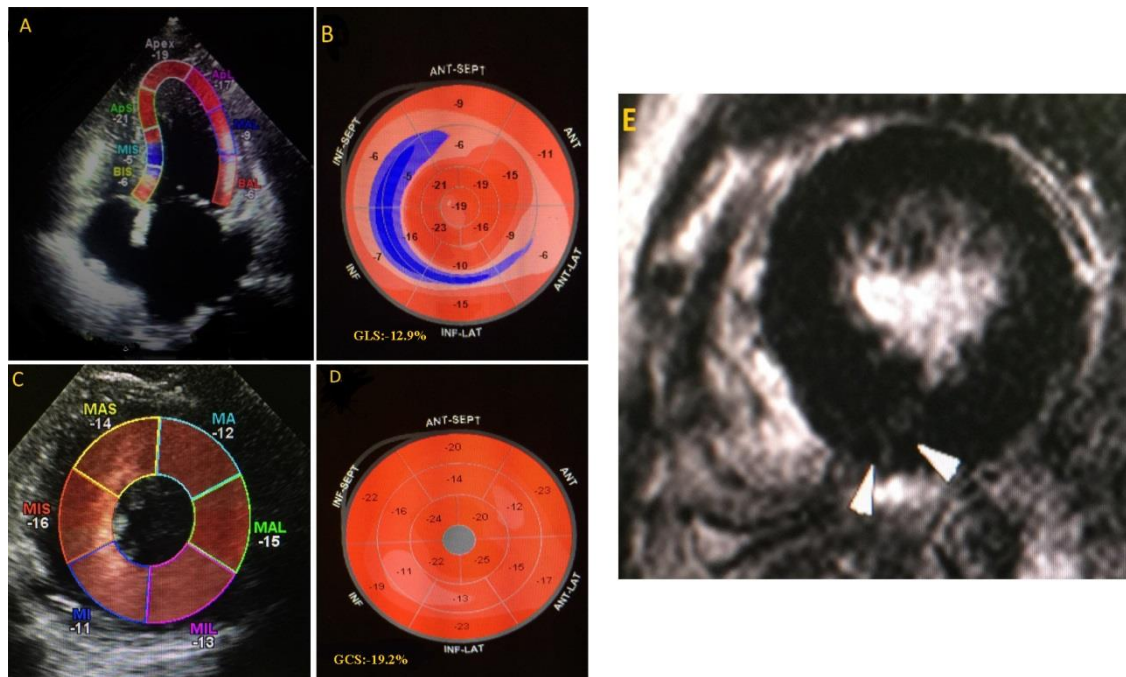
A 60-year-old woman with obstructive hypertrophic cardiomyopathy and an ejection fraction of between 50% and 55% was admitted with pulmonary edema. (A): Two-dimensional speckle-tracking transthoracic echocardiography (TTE) in the 4-chamber view shows reduced segmental longitudinal strain, especially in the base and mid of the inferoseptal (most hypertrophied segments) portions. (B): Two-dimensional TTE global longitudinal strain (GLS) bulls' eye shows reduced GLS (-12.9%). (C): Two-dimensional speckle-tracking echocardiography in the mid-short-axis view shows reduced circumferential strain in the mid-segments of the left ventricle. (D) Two-dimensional TTE global circumferential strain (GCS) bulls' eye shows reduced GCS (-19.2%). E: Cardiac magnetic resonance imaging late gadolinium enhancement (LGE) shows small fibrosis with low percentage LGE (2% – 3%).
